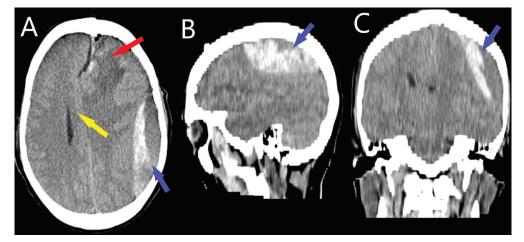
(A, B and C). CT scan of the brain presenting three projections (axial, sagittal and coronal) plane with the presence of a hyperintense collection in the left parieto temporal with evidence of epidural hematoma. Panel A, B and C with blue arrow shows the epidural hematoma. The red arrow in Panel A shows postoperative edema at the site of the extirpated meningioma, the yellow arrow in Panel A, shows the dislocation of midbrain structures, which is 0.7 mm from the midline
